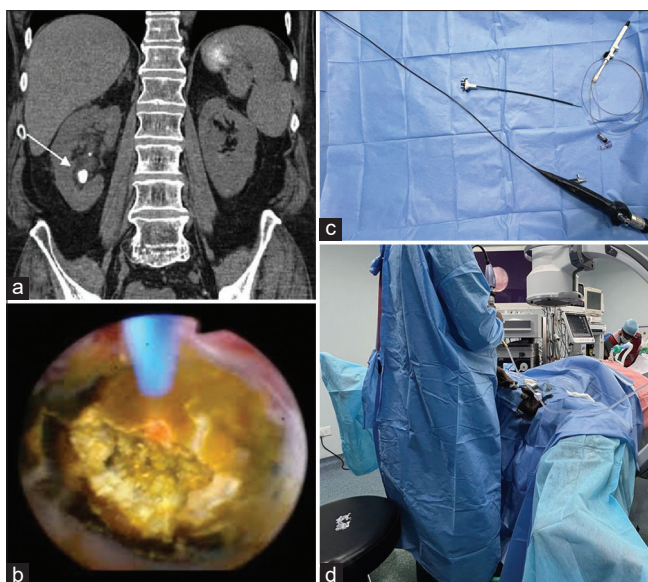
Real-time tilt-retrograde intrarenal surgery (T-RIRS) in progress. (a) Computed tomography showing the lower polar stone, (b) Stone fragmentation in progress, (c) flexible ureteroretinoscope FLEX-X2S used in our study, (d) real-time patient positioning for T-RIRS
